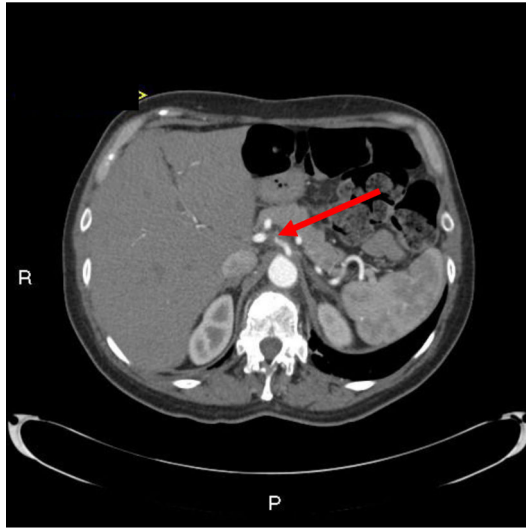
Computed tomographic angiography (CTA) 4 days after diagnosis: The CTA confirmed celiac arterial dissection. No major change in the appearance of this process compared with previous CT, as shown by the arrow. No pseudoaneurysm formation. There is no evidence for hepatic or splenic infarction. The aorta is unremarkable and unchanged.
